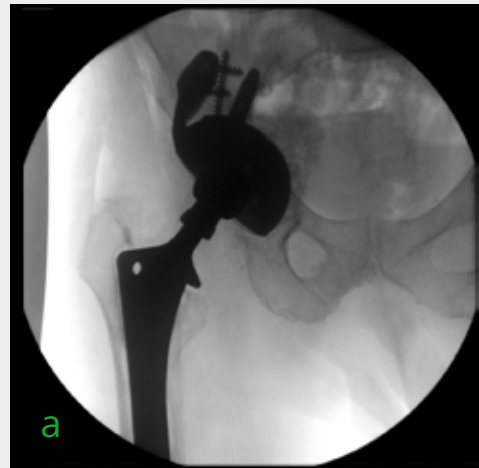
Intraoperative X-ray control of the implant position, very good defect reconstruction
